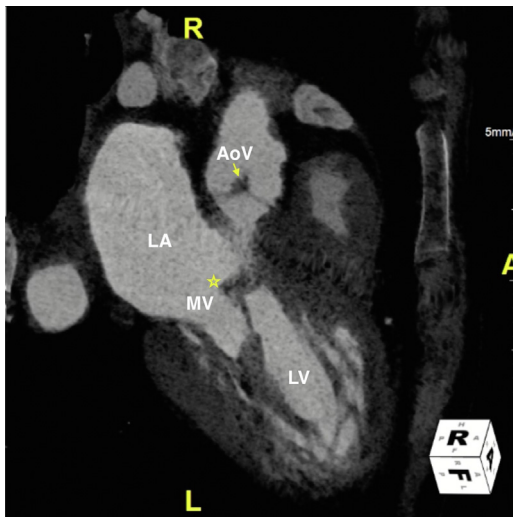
Parasternal Long-Axis View of the Mitral Valve
